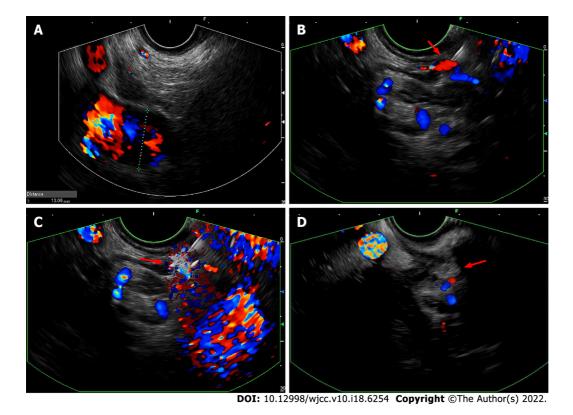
Endoscopic ultrasound images. A: Endoscopic ultrasound revealed an enlarged portal vein; B: A confluence of gastric varices was identified and selected as the injection site (red arrow); C: Undiluted N-butyl-2-cyanoacrylate (red arrow) was injected into the selected gastric varix via a 22-gauge needle; D: Hyperechoic fillings (red arrow) and decreased blood flow signals were observed after injections.
